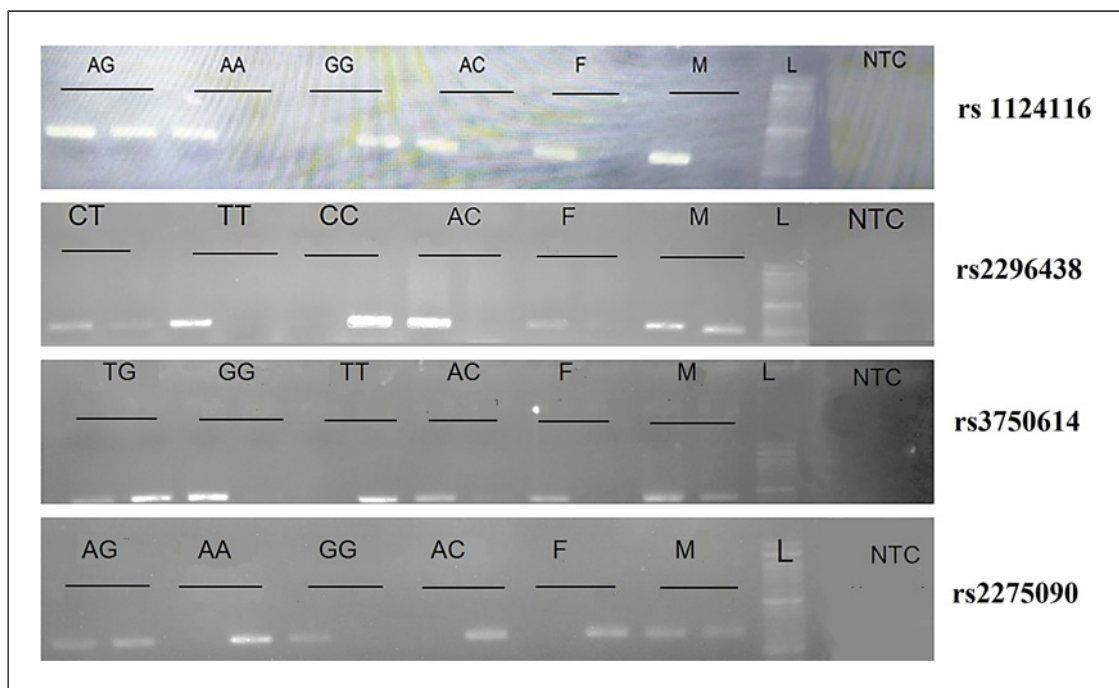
ARMS-PCR for all 4 SNPs in the family of F11. Two nonidentical letters indicate heterozygous genotype of that SNP (AG-CT-TG-AG) and two identical letters indicate homozygous genotype of that SNP (AA-GG-TT-CC-TT-GG-AA-GG). AC, affected child; F, father; M, mother.
